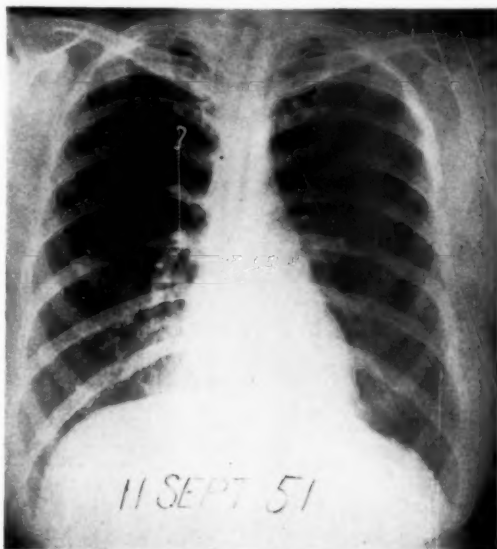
Roentgenogram of Case 1 showing notching along the inferior border of the ribs posteriorly from the fourth to the tenth ribs on each side. The aortic knob is not visualized. (Courtesy of Letterman Army Hospital Photographic Laboratory Neg. No. L-7131-2.)
